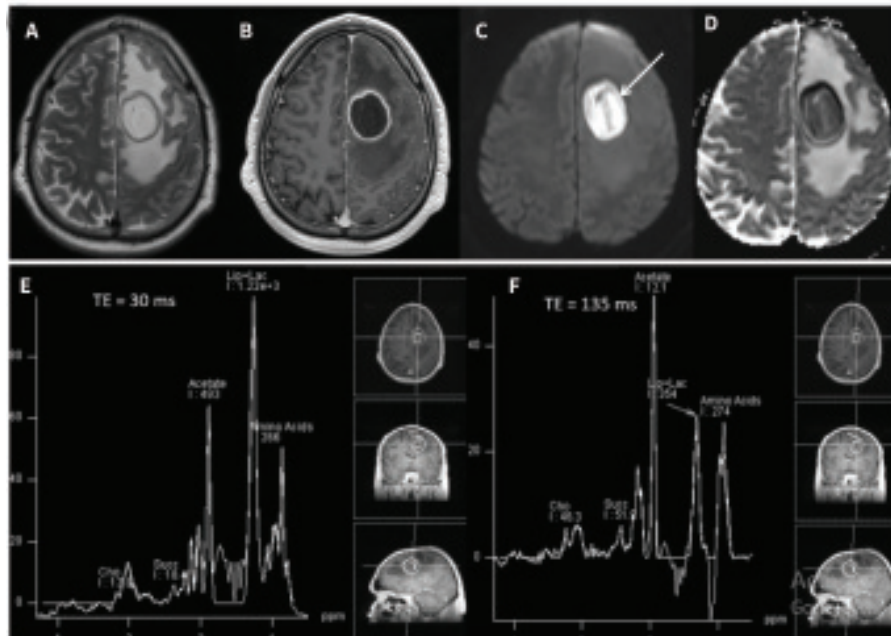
Figure (A-D) Conventional MRI: and MRS (E-F)
